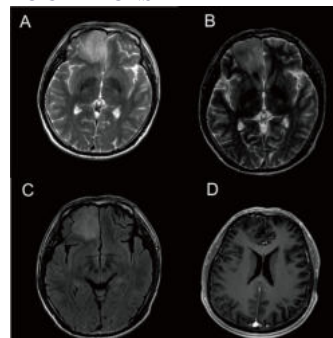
Cranial MRI images of the patient in case 1
